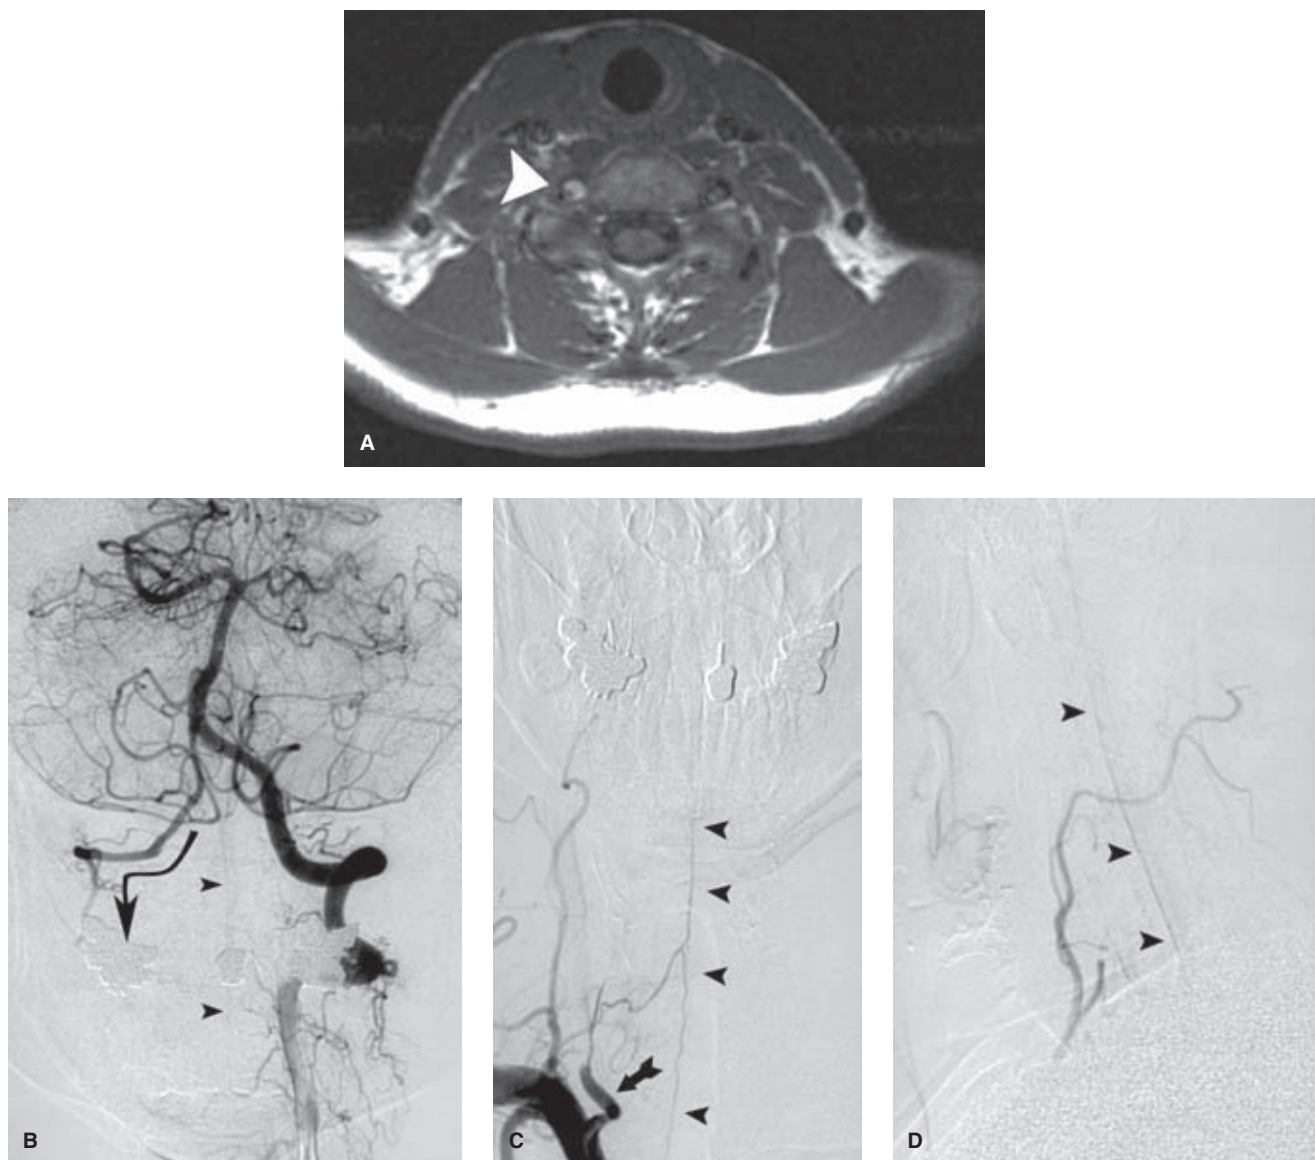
(A–D) Vulnerability of the anterior spinal artery. A middle-aged female complained of neck pain, assumed to be musculoskeletal in origin. When she developed lower extremity fluctuating paraplegia, cord compression from a disc herniation was suspected. However, an MRI demonstrated (*arrowhead* in A) a flow abnormality in the right vertebral artery suspicious for dissection. An angiogram of the left vertebral artery (B, AP view) showed retrograde opacification down the right vertebral artery that did not wash away, indicating compromise of flow in the right vertebral artery. The anterior spinal artery (*arrowheads* in B) was prominently seen on this injection, filling down from the vertebrobasilar junction. The right vertebral artery injection (C, AP view; D, lateral view) shows that the artery (*arrow* in C) terminates in a ragged taper, indicating the intraluminal presence of clot. Out of this tapered segment of artery arises the anterior spinal artery (*arrowheads*). In this case, the anterior spinal artery is larger than the average, suggesting that if the ischemia that had brought this patient to attention had become permanent, she probably would have sustained an extensive infarction of the spinal cord.
